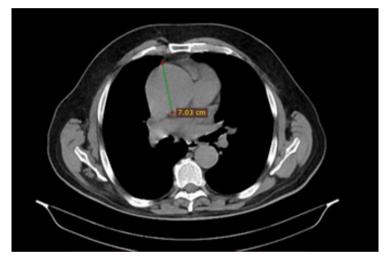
Initial CT (Computed Tomography) scan on admission showcasing an ascending aorta diameter of 7.03 cm (green line).
